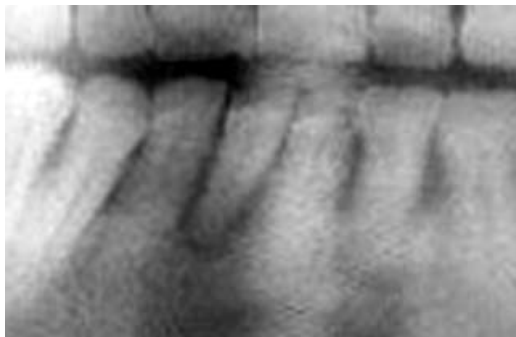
Radiographic view of Case 3.
